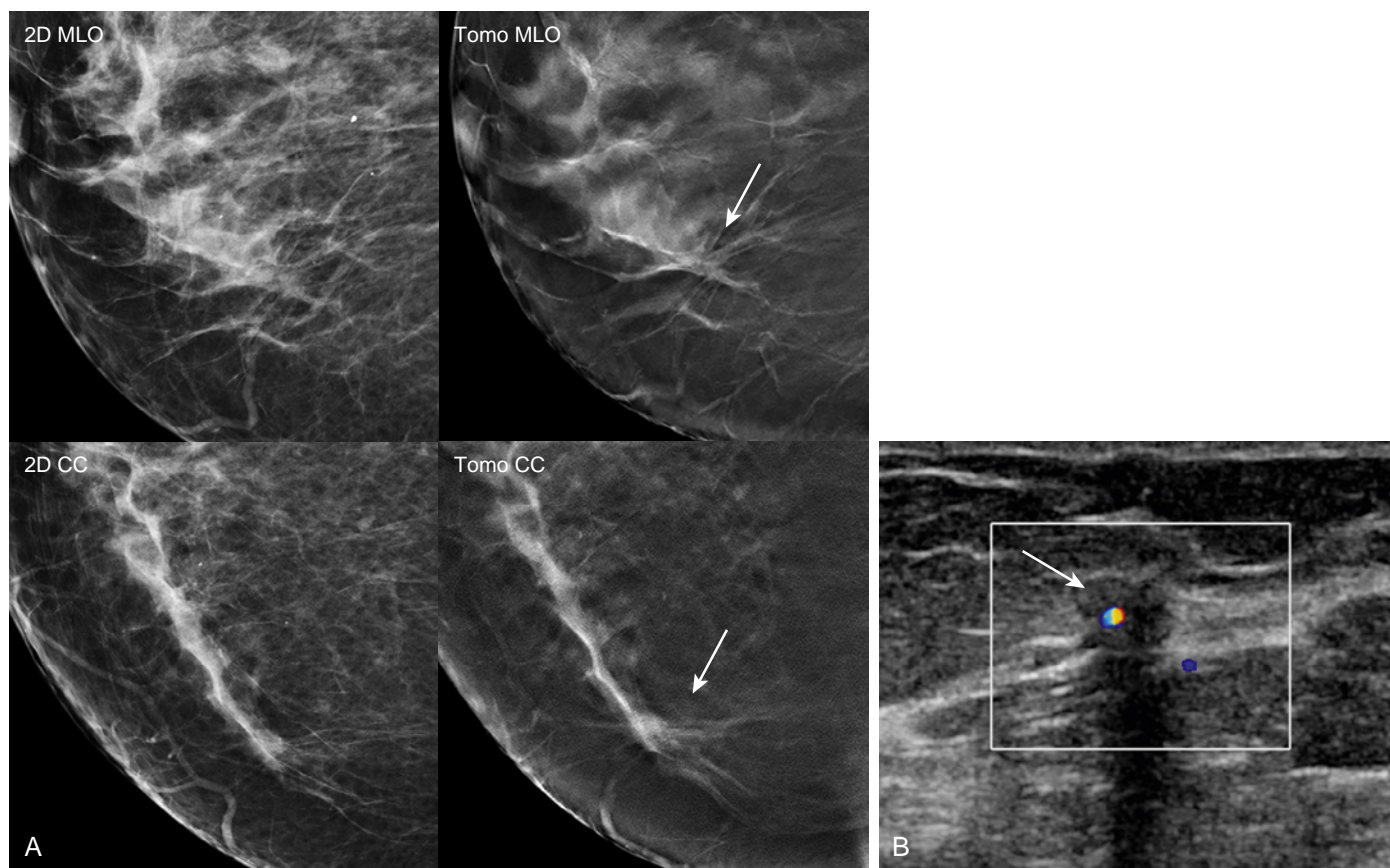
2D occult infiltrating ductal cancer in scattered fibroglandular breast tissue. (A) Close-up views of a screening mammogram in a 57-year-old woman demonstrates a small spiculated mass in the right lower-inner quadrant that is obvious on tomosynthesis (*arrows*) but very subtle on the 2D images. (B) Targeted ultrasound demonstrates a corresponding hypoechoic mass with indistinct borders, posterior acoustic shadowing, and internal vascularity (*arrow*). Ultrasound-guided core needle biopsy and surgical excision yielded infiltrating ductal carcinoma, grade 1, ER/PR+, Her2–.
